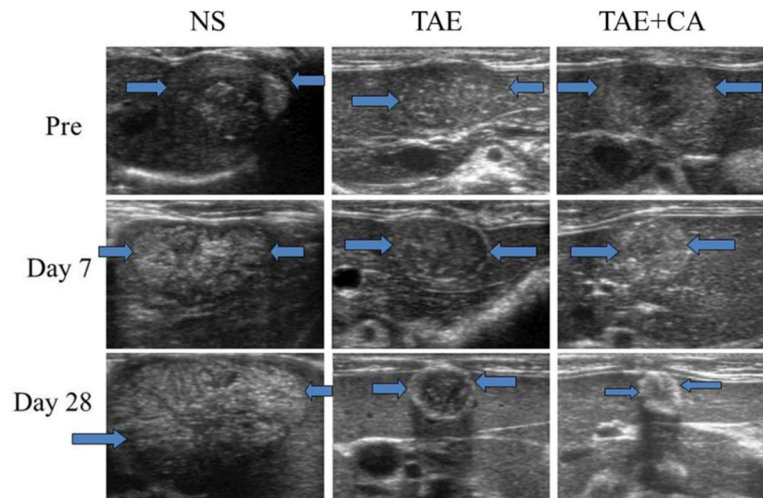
Representative ultrasound (US) images of normal saline control group (NS), embolization only group (TAE), and embolization with caffeic acid group (TAE+CA) at day 0, 7, and 28. Note significant decrease in size of the TAE+CA group when compared with NS and TAE groups. TAE+FA groups showed similar decrease in size and changes in echogenicity when compared to TAE+CA.
